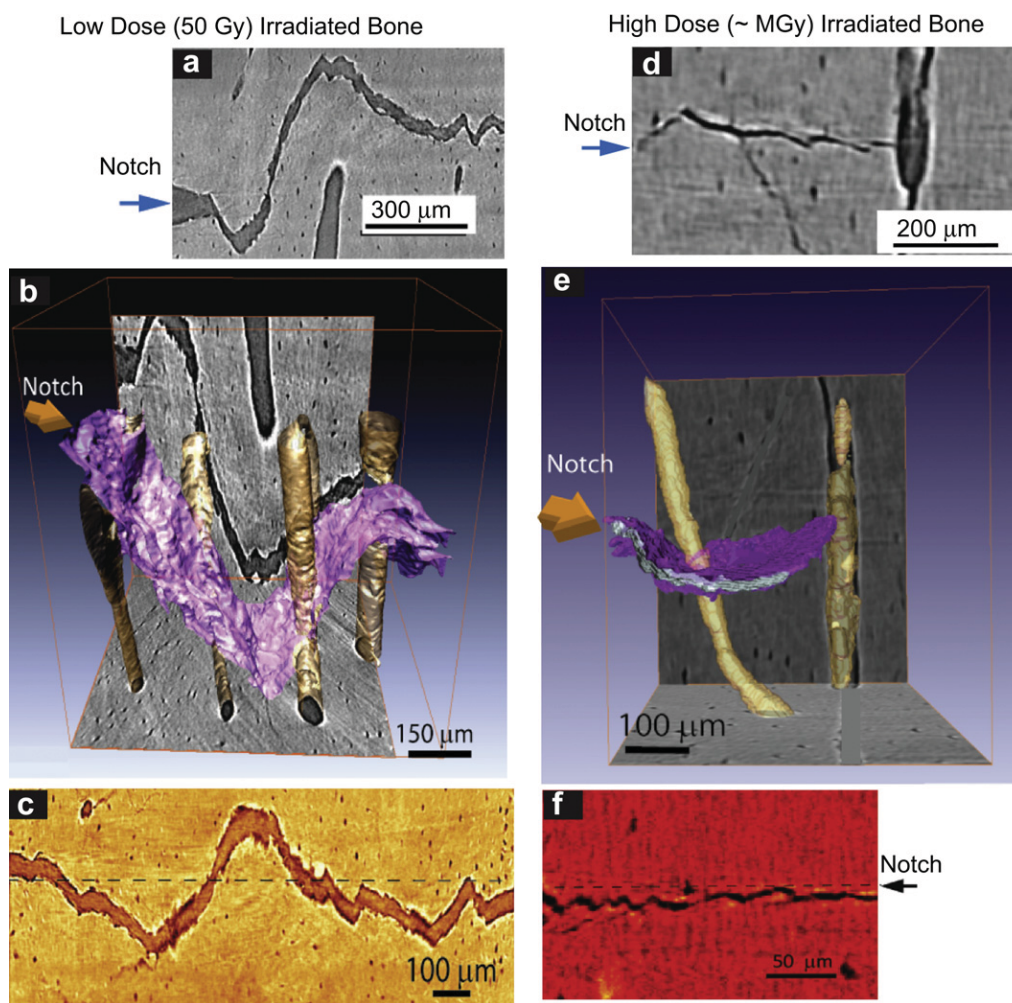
X-ray computed micro-tomography of crack paths in hydrated human cortical bone in the transverse orientation following (a–c) low dose (50 Gy), and (e–g) high dose (~MGy) x-irradiation. Images show crack paths: (a) & (d) x-ray tomographs from side-view perpendicular to the crack plane, (b) & (e) 3-D x-ray tomography images of these paths (3-D crack surface is in purple; Haversian canals are yellow), and (c) & (f) 2-D tomographs of the paths from the back face of the sample. The crack deflects on encountering the osteons; such crack deflection and crack twisting is the prime extrinsic toughening mechanism in bone in the transverse orientation. Note, however, that the frequency of such deflections increases with irradiation while their severity decreases, resulting in less meandering crack paths in the irradiated bone. (For interpretation of the references to colour in this figure legend, the reader is referred to the web version of this article.)
